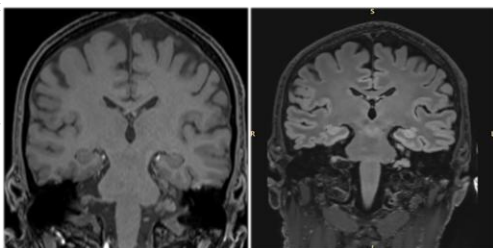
Repeat MRI (December 2024) in T1 (left) and FLAIR (right) revealed no pathological finding
